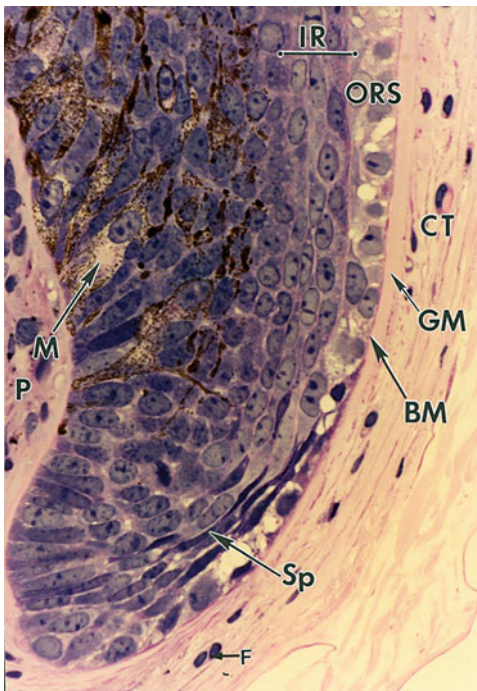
The cells of the matrix and of the outer root sheath (ORS) are aimed upward. Note the large melanocytes (*M*) and also some dark spinous cells (*Sp*), which separate the inner root sheath (*IR*) from the outer root sheath (ORS). These dark cells are the companion layer's cells that are produced in the bulb. One can also see the dermal papilla (*P*), the connective tissue sheath (*CT*), and a thin basal membrane (*BM*) inside the vitreous membrane (*GM*). Fibroblasts (*F*) can be seen in the connective tissue sheath
